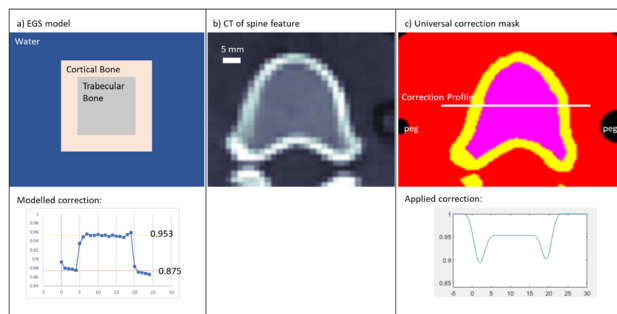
a) the EGS model to calculate correction factors. b) CT data. c) The universal mask used to apply the film correction
